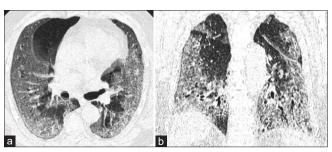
(a and b) Patient having subpleural ground glass opacities on HRCT chest
